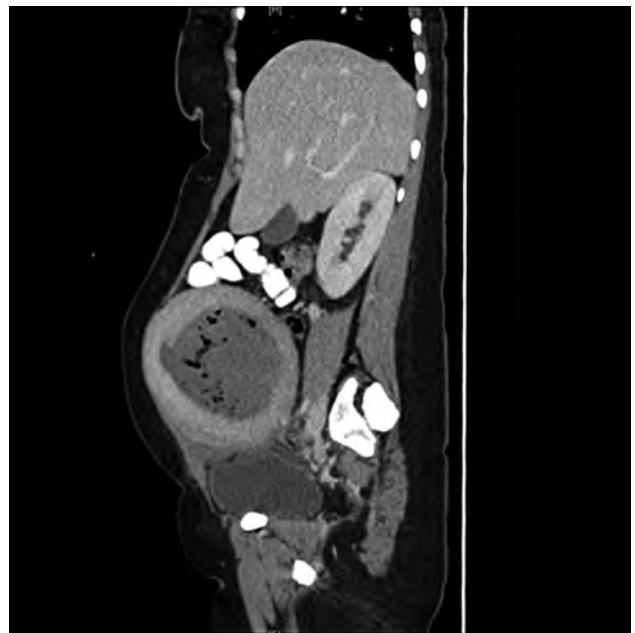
CT sagittal view showing air pockets.
